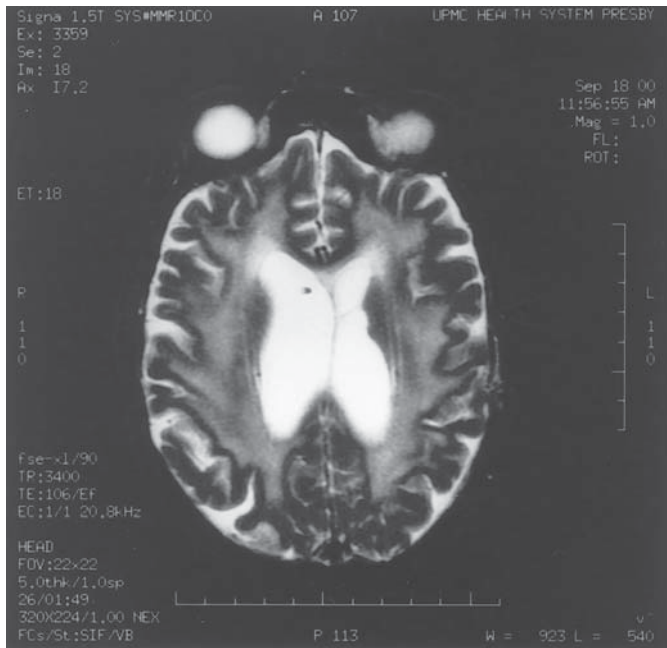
Leukoencephalopathy: A 75-yr-old woman with primary central nervous system lymphoma was treated with CHOP, 10 doses of intraventricular methotrexate, and fractionated whole brain radiotherapy (5040 cGy in 28 fractions). Her tumor responded and never recurred. Three years later, she noted moderate short-term memory deficits and gait unsteadiness. MR scanning (T2-weighted image) demonstrated extensive periventricular white matter changes. The patient's dementia progressed, and she developed rigidity and mutism prior to her death 1 yr later.
